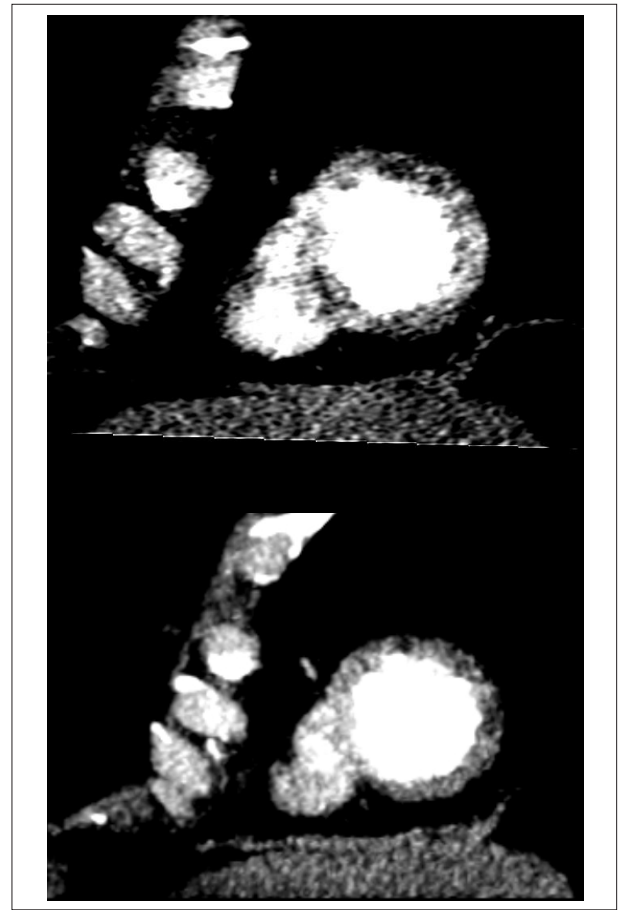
64-channel Cardiac Computed Tomography, effort and rest stage, reveals perfusion defect in the anteroapical and lateral-apical segments of the left ventricle in the post-stress images with normal perfusion in rest.
